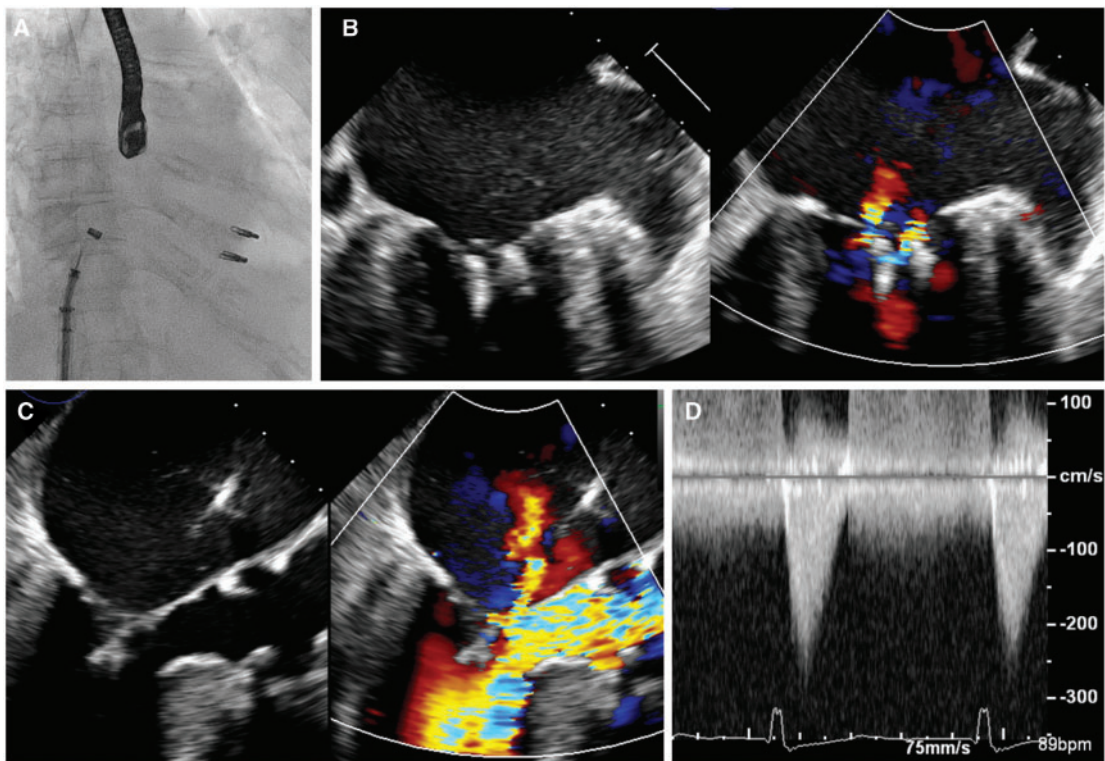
(A) Fluoroscopic view showing second clip deployed lateral to the first clip. Transoesophageal echocardiographic images showing (B) residual 1–2+ mitral regurgitation in the intercommissural view, and (C) reduction of systolic anterior motion-related mitral regurgitation in the left ventricular outflow tract view. (D) The left ventricular outflow tract peak pressure gradient was reduced to 33 mmHg.
